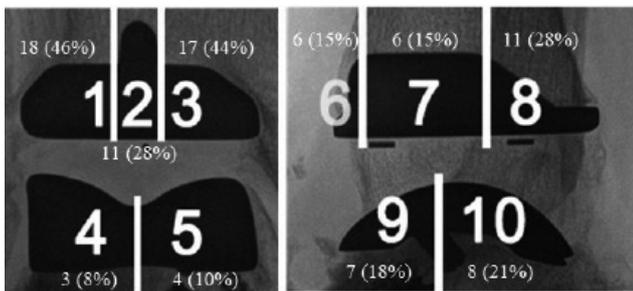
Number of patients with radiolucent lines (%) shown located in the radiographic zones. Zones 1-5 in AP-view; Zones 6-10 in lateral view.
